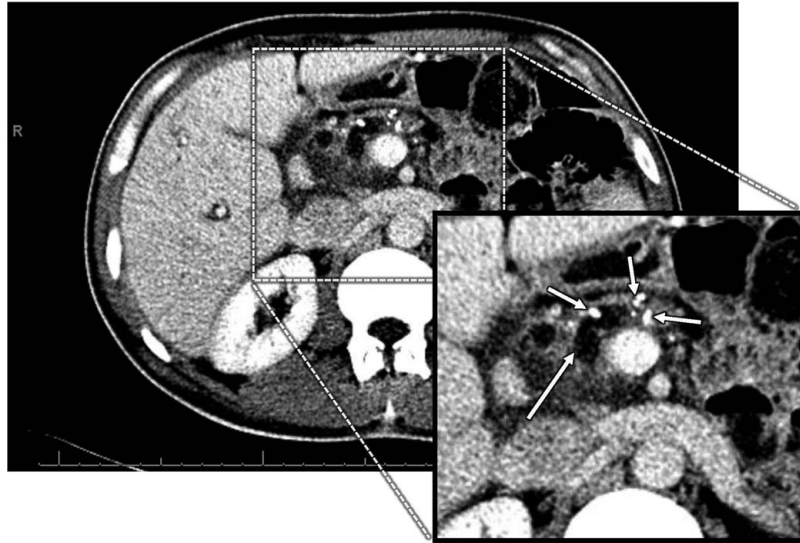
CT scan of the abdomen in the patient with calcific chronic pancreatitis. Axial view demonstrating dilated pancreatic duct containing air in head and neck of the pancreas and coned in view with dilated duct in head and neck of the pancreas. Long arrow: dilated pancreatic duct. Small arrows: calcifications.
